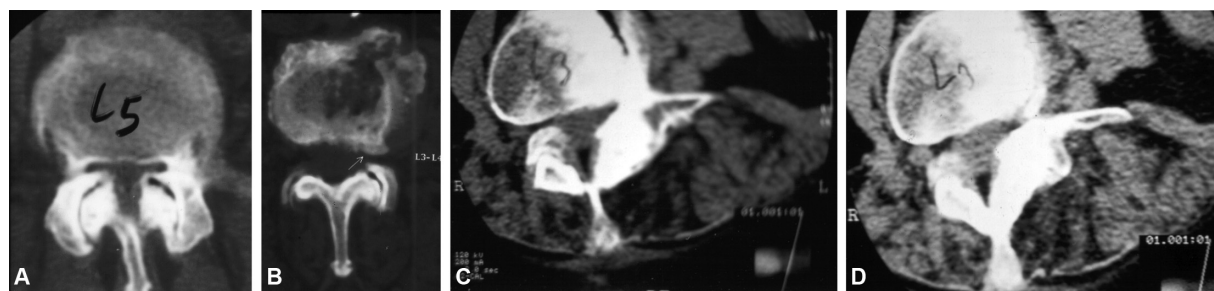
Axial computed tomography images showing: Central stenosis from (A) lateral recess and (B) foramen; (C and D) Degenerative scoliosis with vertebral rotation and laterolysis with foraminal stenosis.
